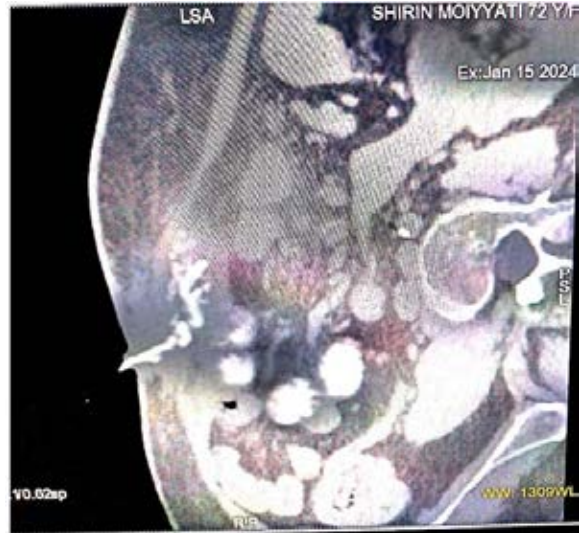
CT Sinogram showing a linear enterocutaneous tract
